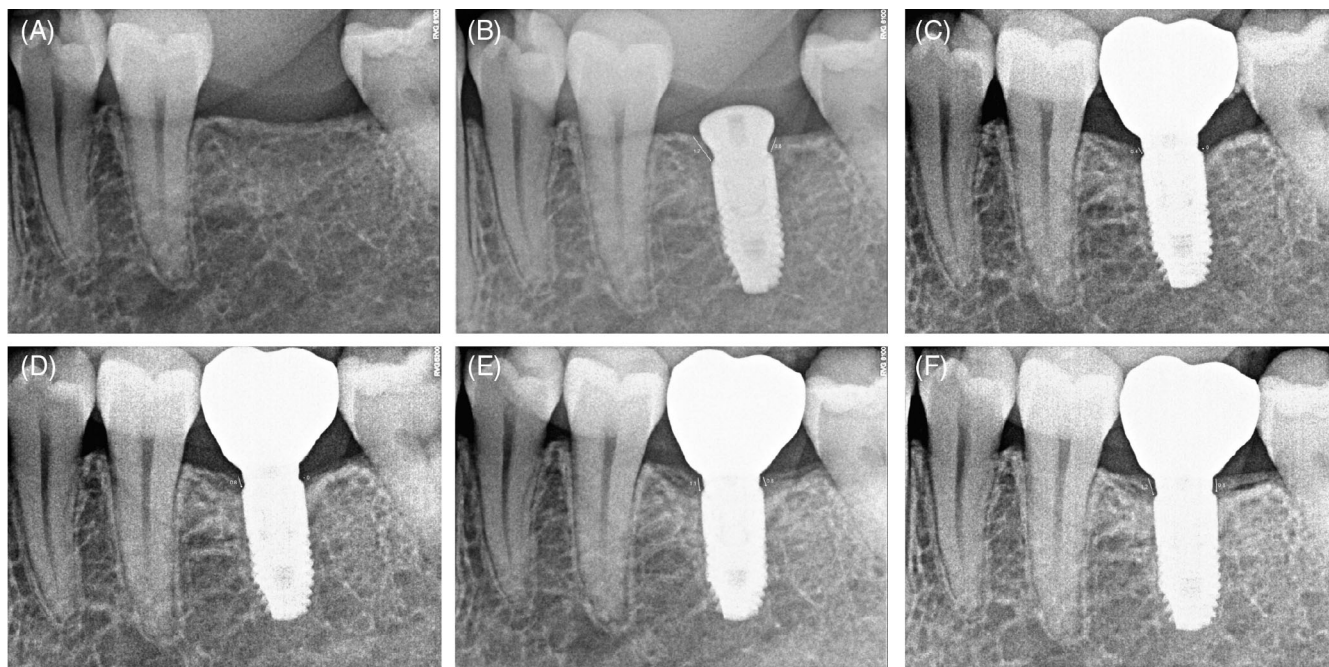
X-rays taken by patients: (A) baseline (Tx), (B) after crown placement (To), (C) 1 month after crown placement (T1), (D) 3 months after crown placement (T2), (E) 6 months after crown placement (T3), (F) 12 months after crown placement (T4).
